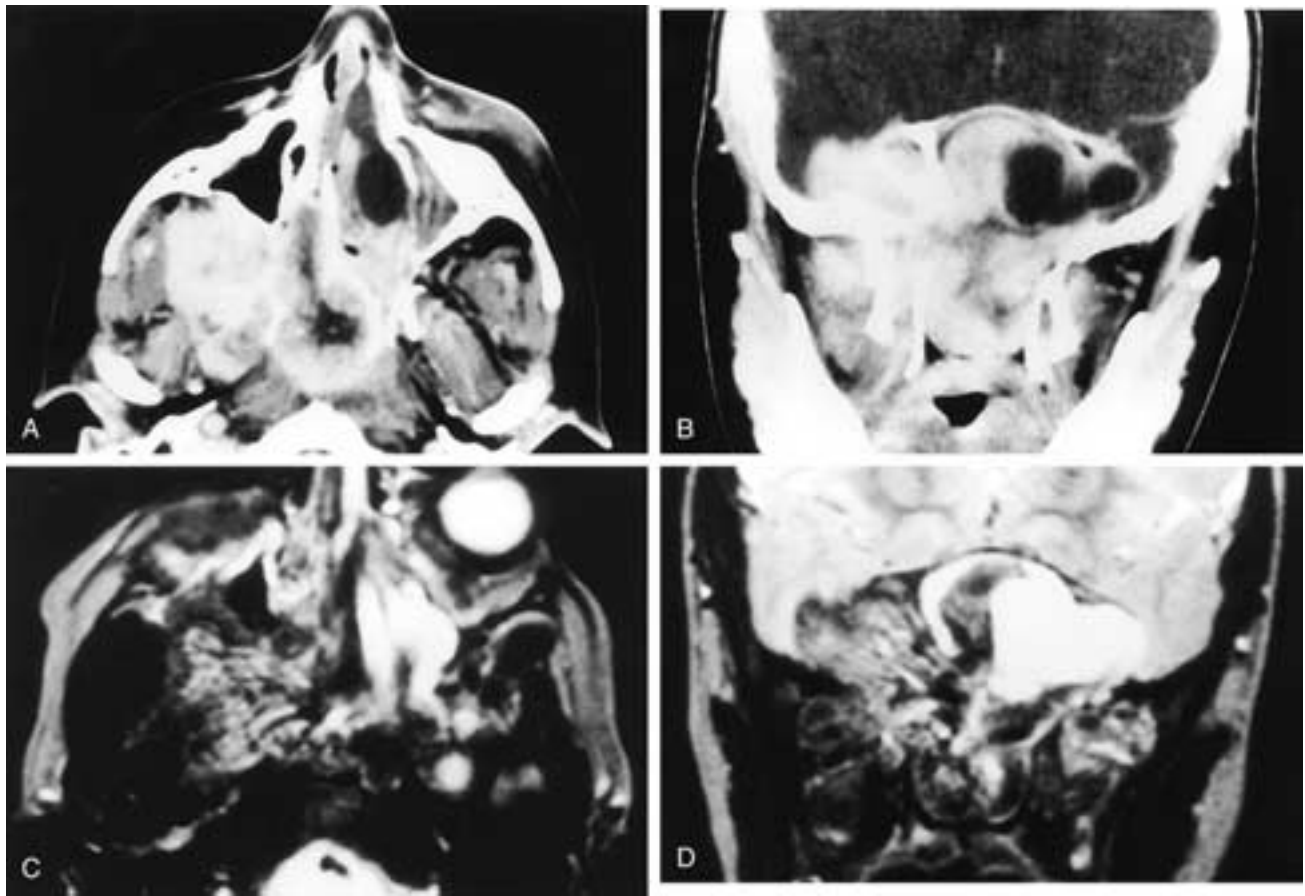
Axial (A) and coronal (B) CT scans show a large enhancing mass that fills the nasopharynx and nasal fossae, bows the posterior wall of the right maxillary sinus forward, and extends into the right infratemporal fossa. The tumor has also destroyed the floor of the sphenoid sinus and the right middle cranial fossa. There is a nonenhancing region in the vicinity of the left sphenoid sinus. Axial T2-weighted (C) and coronal (D) proton density MR images show that the mass is filled with serpiginous signal voids, reflecting its highly vascular nature. The left sphenoid sinus is filled with high T2-weighted fluid. This patient had a large angiofibroma with a left sphenoid sinus mucocele. The skull base was not destroyed, but only deossified from the chronic pressure of the tumor. Both cavernous sinuses were intact but were elevated by the mass.
